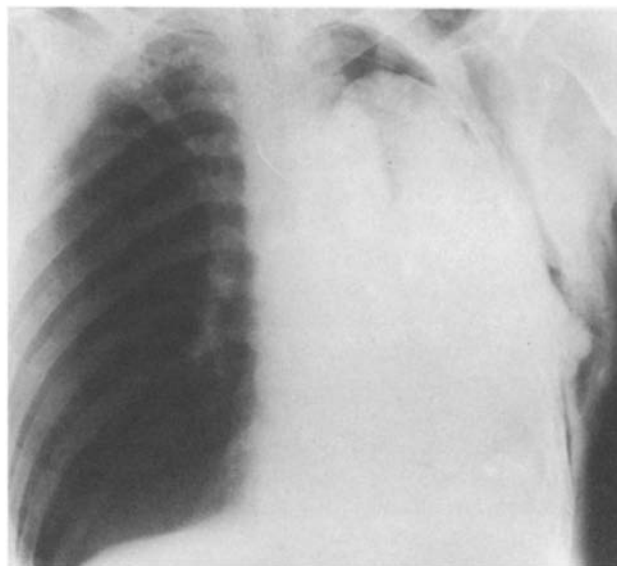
Chest X-ray revealing complete collapse of remaining left lung
